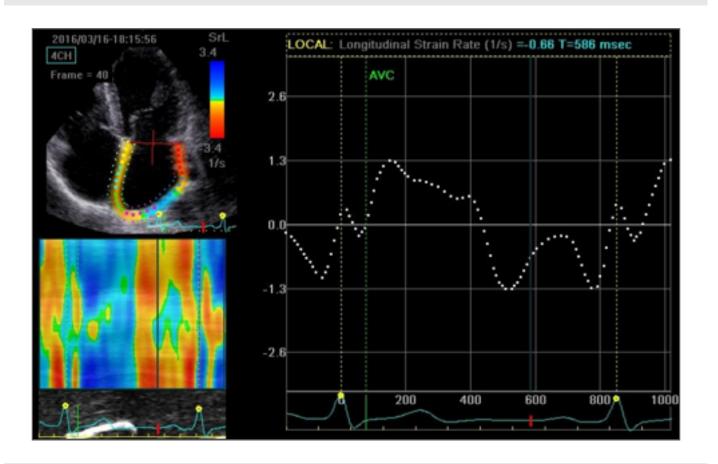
Global longitudinal left atrial strain rate from an apical four-chamber view of a severe iron deficiency anaemia patient.
